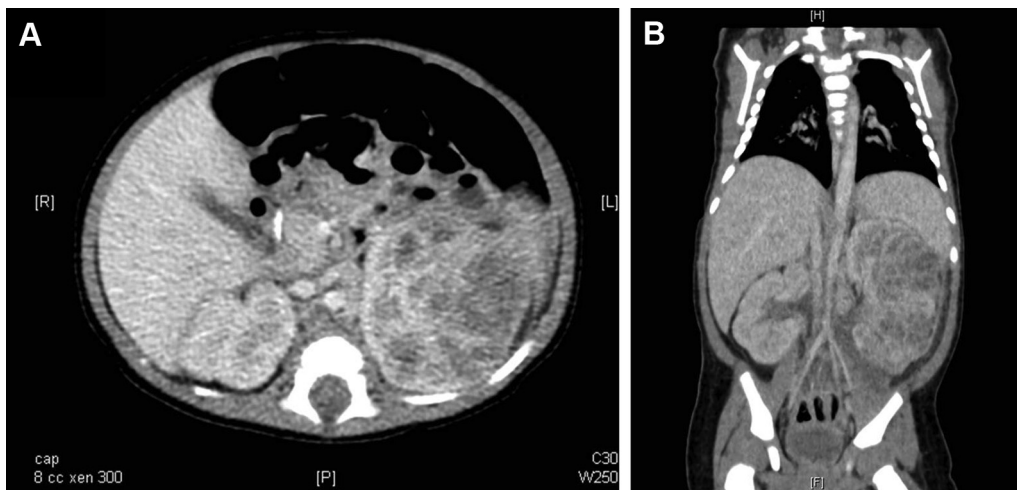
(A and B) Computed tomography scan showing a large heterogeneous complex mass, involving most of the kidney parenchyma, and extending to the perinephric fat.
